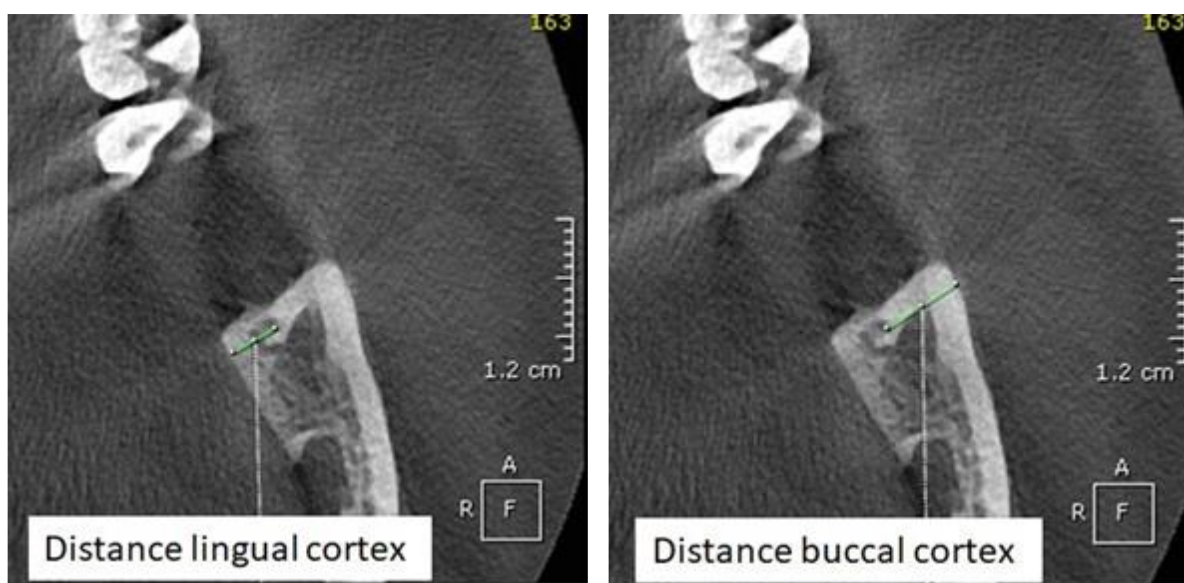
Axial CBCT image. Foramen distance to the buccal and lingual cortex.
